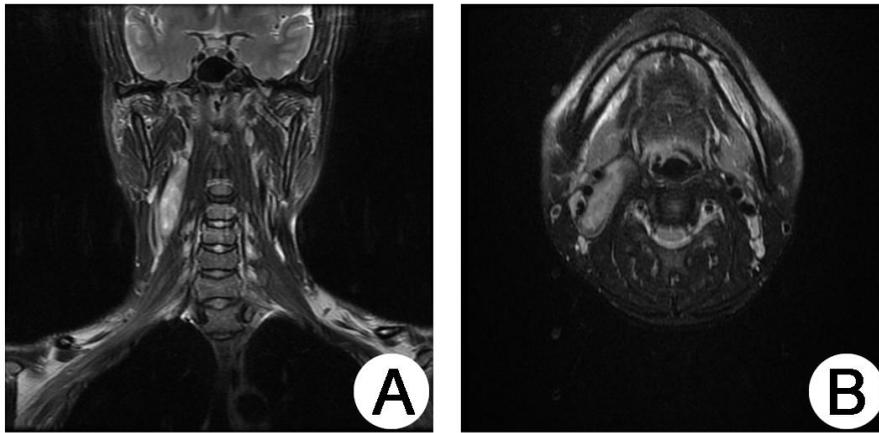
Magnetic resonance imaging showing a hyperdense lesion in the right parapharyngeal as compared to the surrounding muscle with a variable signal and distinct margins on T2-WIFS. (A)coronal view; (B) axial view.
